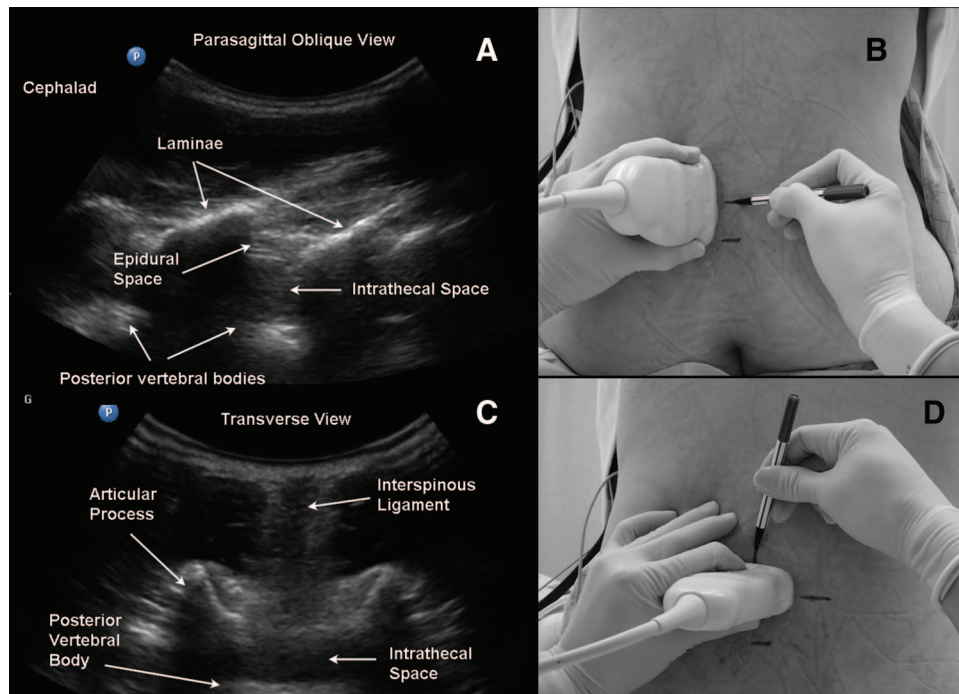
In the paramedian sagittal oblique view, each lumbar interlaminar space is centered in turn on the ultrasound screen (A). A corresponding skin mark is made at the midpoint of the probe's long edge (B). The probe is then turned 90 degrees to obtain the transverse view (C). The midline is centered on the ultrasound screen, and skin marks are made at the midpoint of the probe's long and short edges (D). The intersection of these two marks provides an appropriate needle insertion point for a midline approach to the epidural or intrathecal space at that level. (From *Ultrasound Imaging for Regional Anesthesia: A Practical Guide Booklet*, 3rd edition, Ultrasound for Regional Anesthesia. Used with permission from the publisher.)
